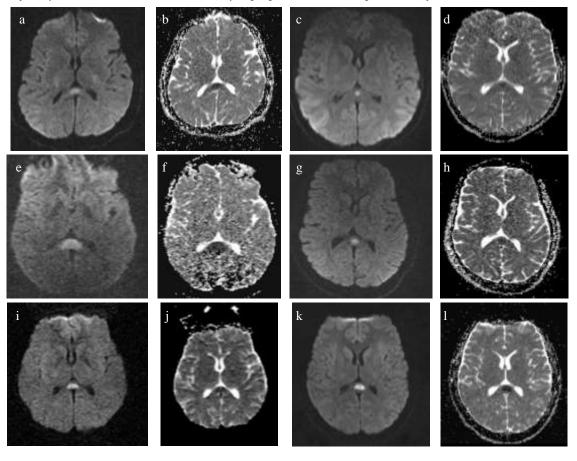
Diffusion weighted MRI and ADC maps of initial MRI examinations of Patient 2 (a, and b), Patient 3 (c and d), Patient 4 (e and f), Patient 5 (g and h), Patient 6 (i and j), and Patient 7 (k and l), respectively, that show diffusion restriction characterized by a high signal in DWI, and a low signal in ADC maps
